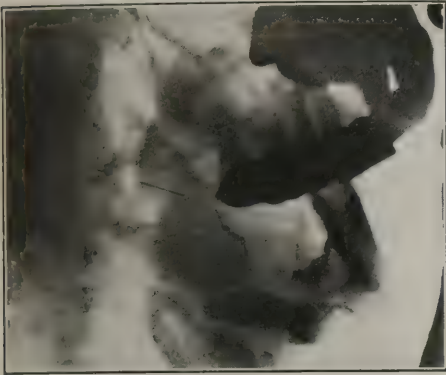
Case 6: Radiograph ten months after operation, showing consolidation.
